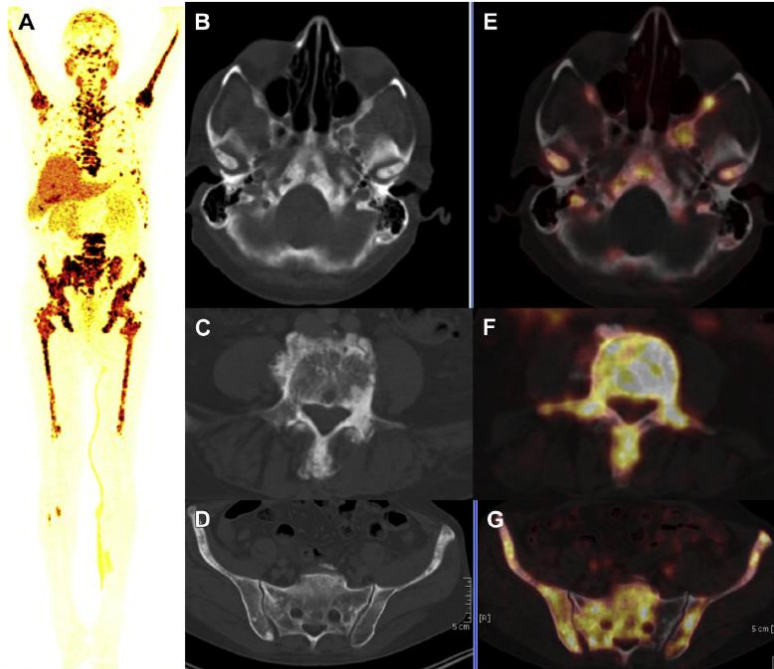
^{64}Cu -PSMA PET/CT demonstrates extensive axial and appendicular skeletal metastases. (A) MIP image. (B-D) Serial axial CT. (E-G) Corresponding PET/CT fusion images.
